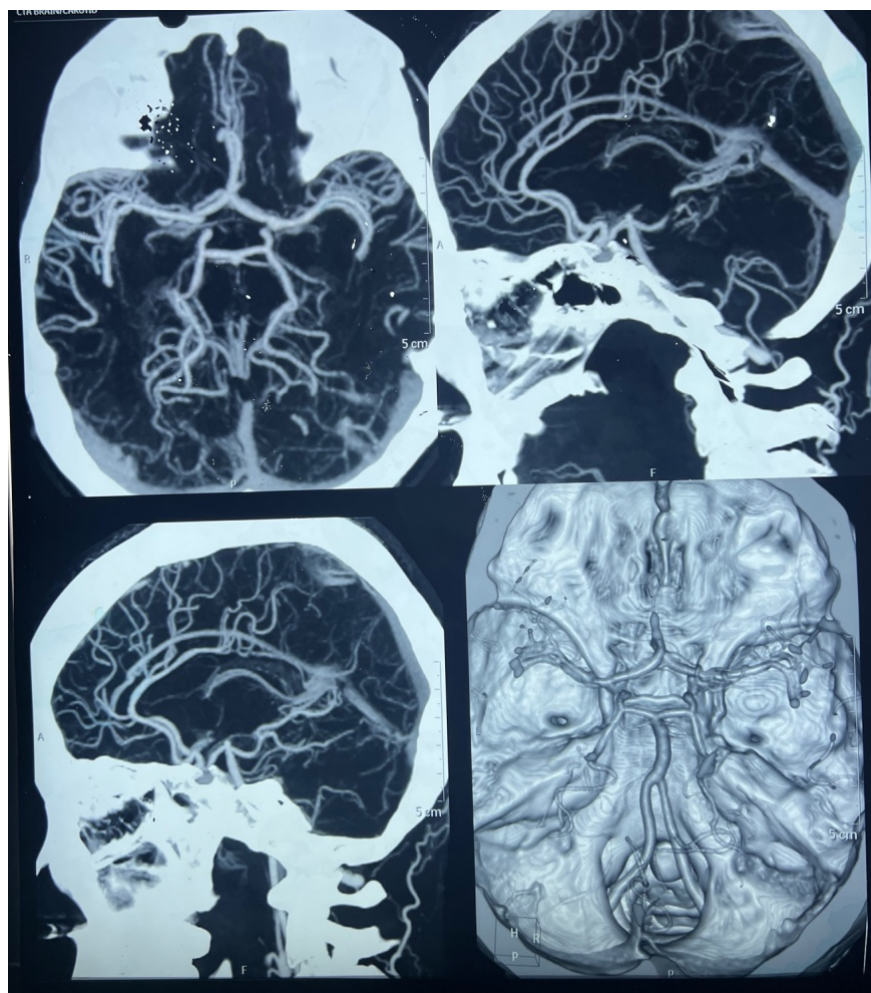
Computed Tomography (CT) angiography of brain showing normal circle of Willis.
